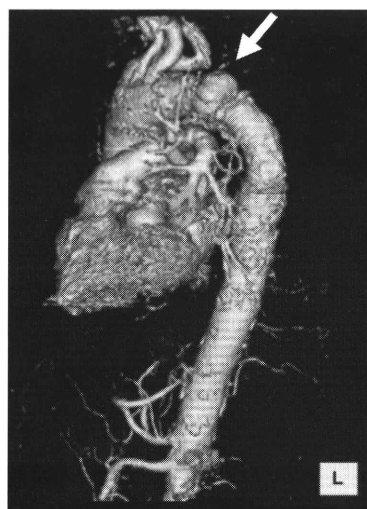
This figure shows the three-dimensional contrast computed tomography image of our patient. A saccular aneurysm, which an arrow sign indicated, is located between the left subclavian artery and the origin of the previous graft.
